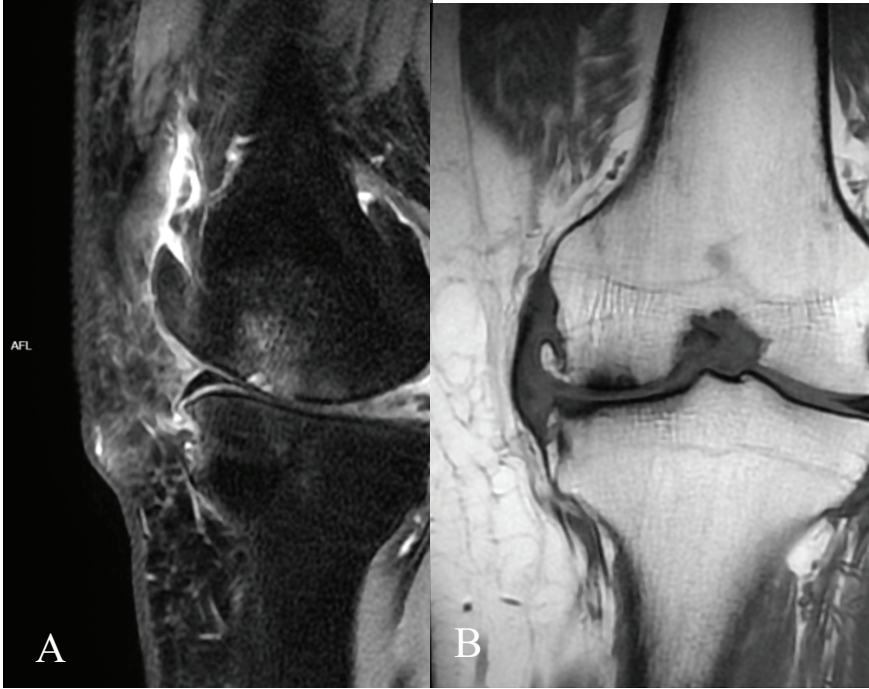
Knee MRI of the patient who will undergo HTO A) lateral view B) anterior-posterior*
